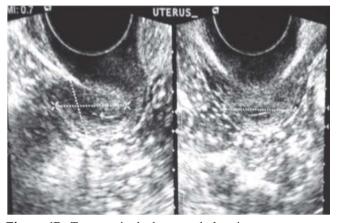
Transvaginal ultrasound showing measurement of the uterine corpus. The corpus was anteflexed and infantile measuring 2.0cm x 2.3cm x 1.5cm. The endometrial lining is thin.
